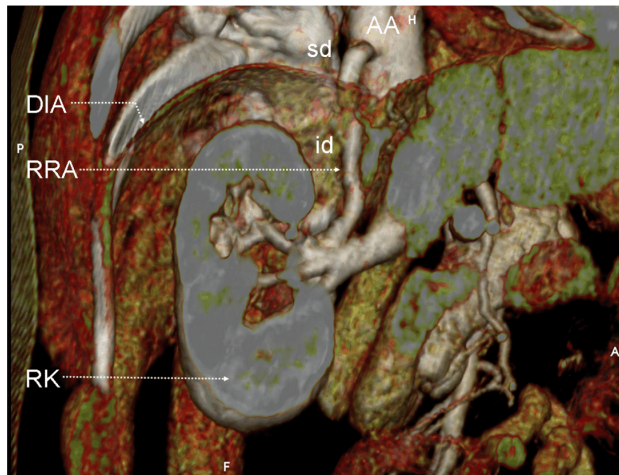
Right supero-lateral volume rendering images demonstrates the supra- and infradiaphragmatic part of the right renal artery: (A) with the liver in situ; (B) after subtraction of the liver. AA: Abdominal aorta; CT: Celiac trunk; DIA: Diaphragm; LIV: Liver; LK: Left kidney; RK: Right kidney; RRA: Right renal artery [id: Infradiaphragmatic part; sd: Supradiaphragmatic part]; SMA: Superior mesenteric artery.
